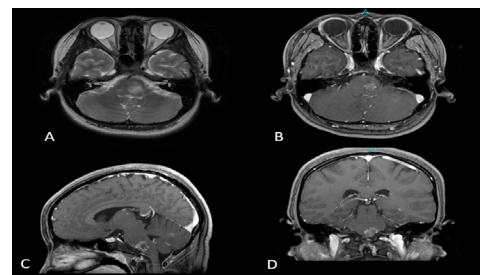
Brain MRI of case 1 before treatment. A: T2WI. B, C, D: Contrast MRI. A tumor is located from the left pons to the left medulla oblongata.
